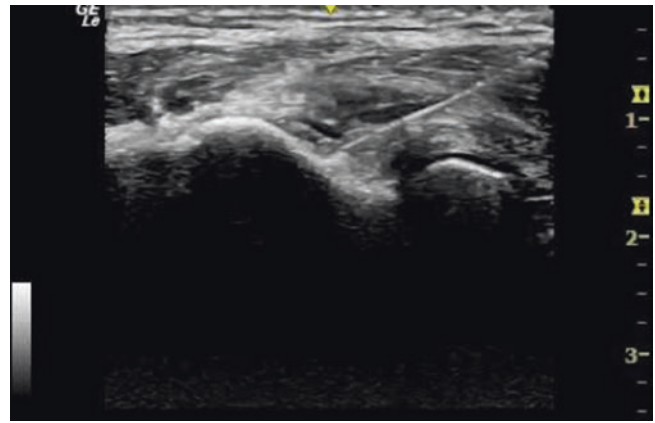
Ultrasound-guided injection by Dr. ChiKai You© (torn radial collateral ligament)
